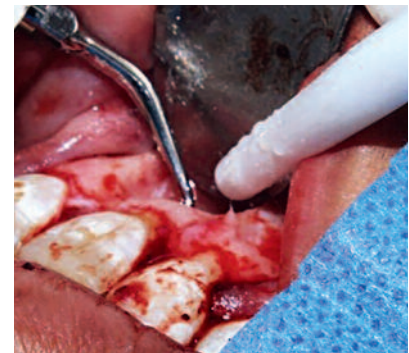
3 mm retrograde cavity with ultrasound.
